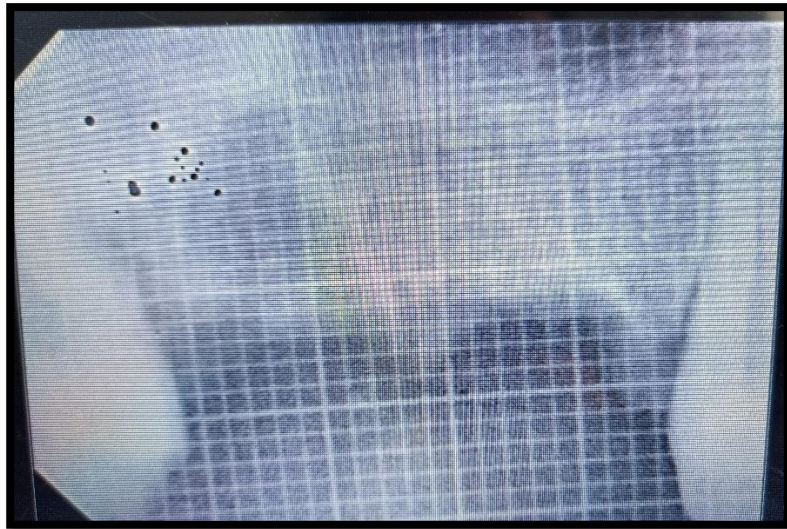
Xray sensor with grid
